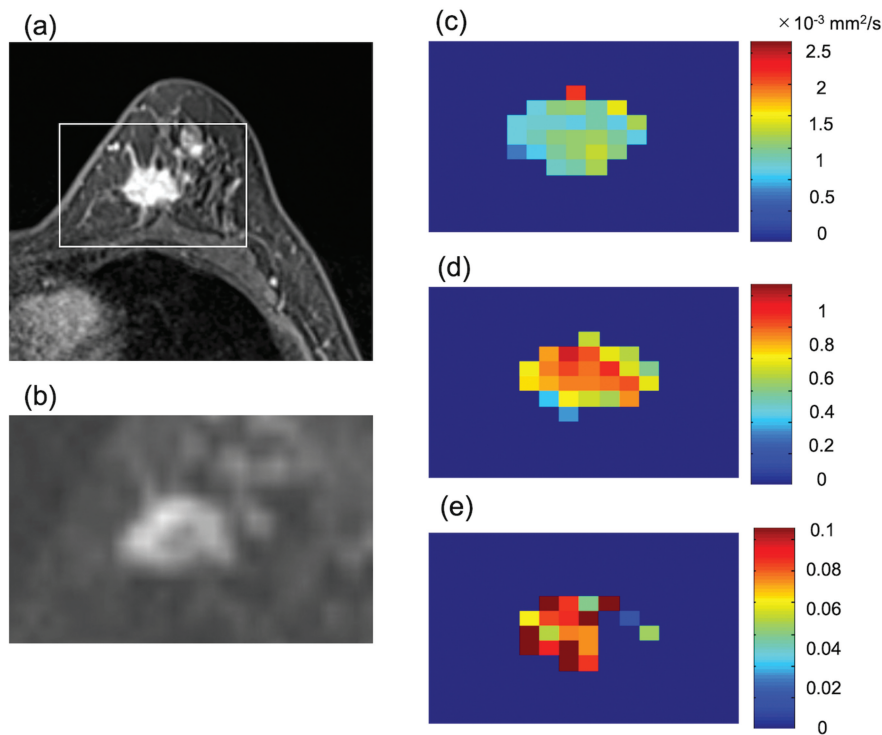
Images of a 62-year-old woman with invasive ductal carcinoma who did not develop distant metastasis. (a) contrast-enhanced axial MR image, (b) DWI ($b = 1500 \text{ s/mm}^2$), (c) ADC_0 map, (d) K map, and (e) f_{IVIM} map. The white rectangle on (a) shows the area covered by the parametric maps. (a) The mass lesion showed heterogeneous enhancement. (b) The lesion shows peripheral high signal intensity on DWI. (c) ADC_0 map shows low values throughout the lesion with a mean value of $1.0 \times 10^{-3} \text{ mm}^2/\text{s}$. (d) The mass shows relatively low mean K values (0.83) with heterogeneous distribution. (e) f_{IVIM} map shows high values throughout the lesion with a mean value of 0.09. ADC, apparent diffusion coefficient; DWI, diffusion-weighted imaging; f_{IVIM} , flowing blood volume fraction; K, kurtosis.
